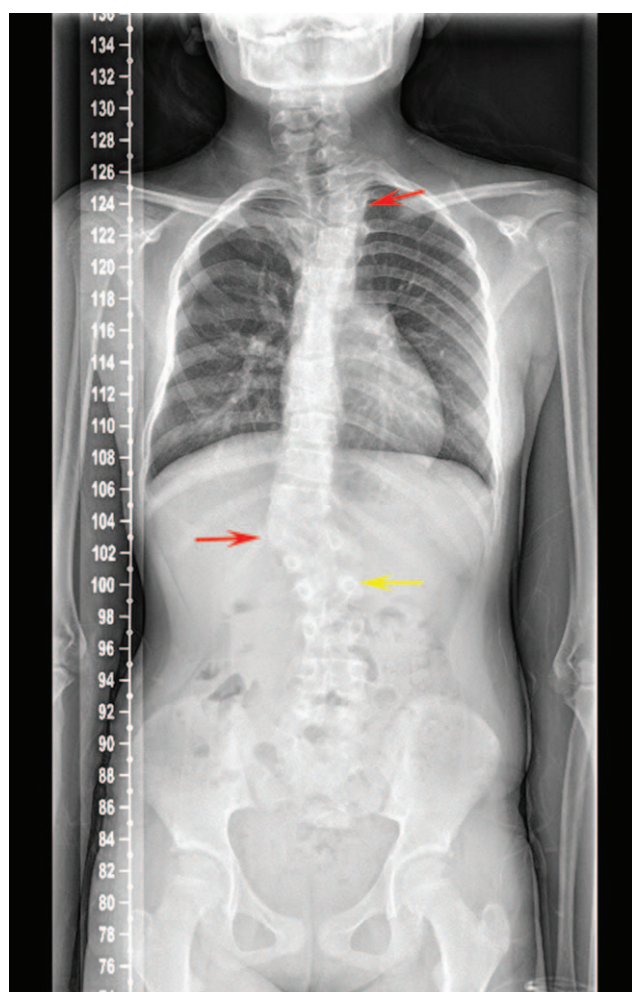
A plain film X-ray revealed scoliosis with butterfly vertebra (yellow arrow) and hemivertebrae (red arrow).
